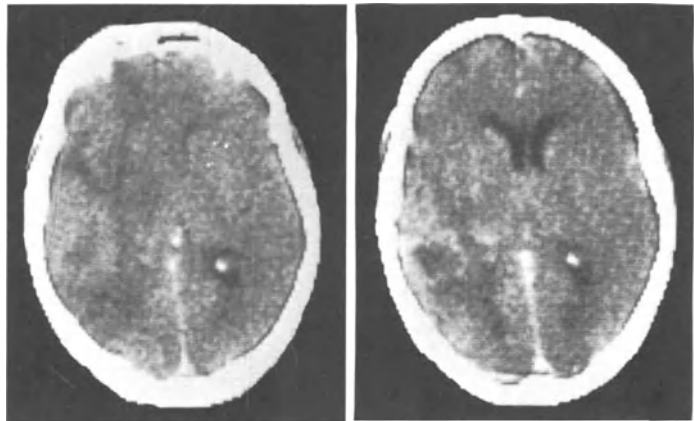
CT showing diffuse brain edema caused by a left-sided temporal glioma compressing the ventricular system. Following the combination therapy (dexamethasone 4x4 mg i.m./die and furosemide 3x40 mg p.o./die) brain edema is disappearing, ventricles are reopening
